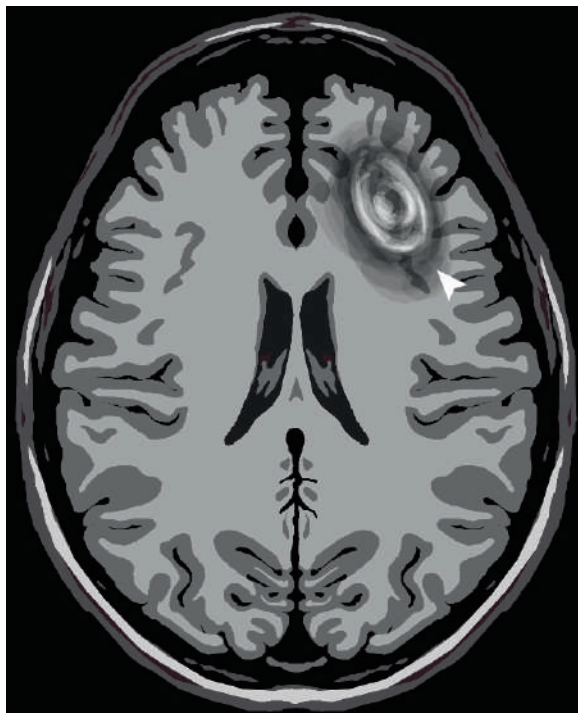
Axial T1W postcontrast MRI shows toxoplasmosis lesion seen in an immunocompromised patient as a rounded lesion with vasogenic edema and ring enhancement (*arrowhead*)
